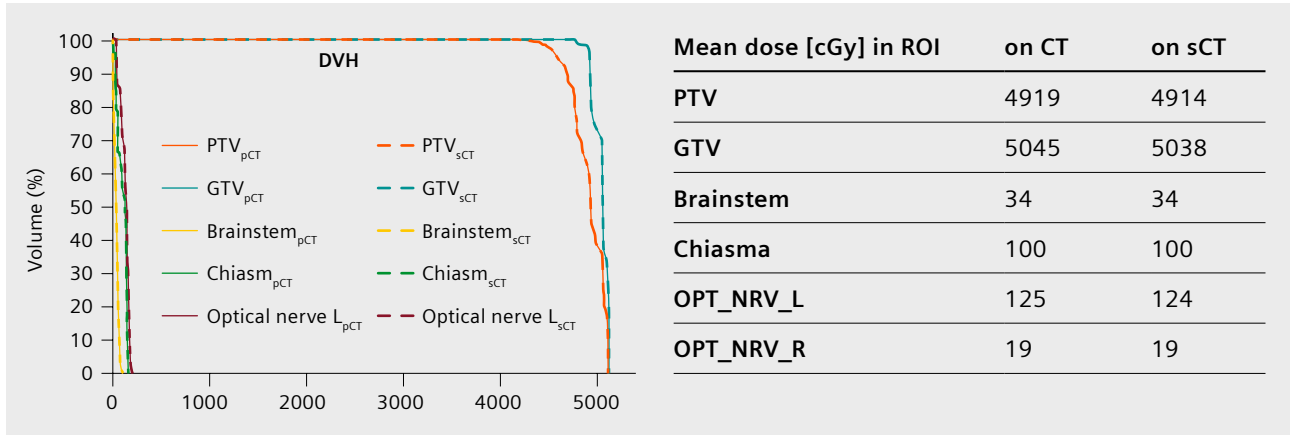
Mean dose on the planning CT and Synthetic CT (sCT) in six regions of interest for one patient.
